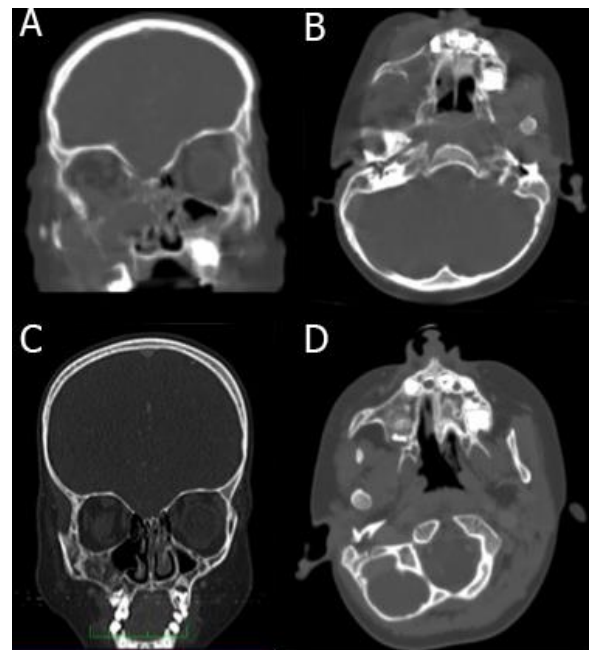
A: Coronal section shows maxillary sinus, nasal and orbital involvement. B: Axial section. C and D: Computed tomography axial and coronal image showing disappearance of previously observed lesions six months after chemotherapy.
